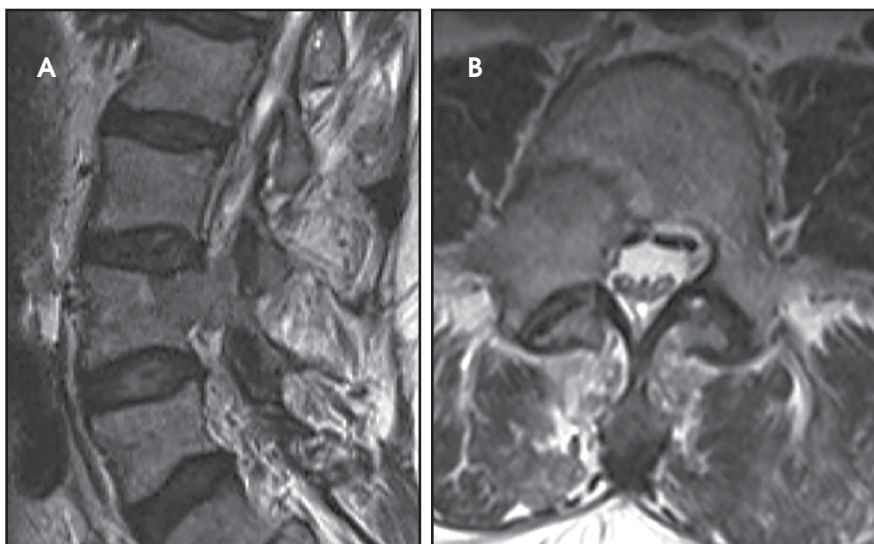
(A) Sagittal and (B) axial T2-weighted MR images of the lumbar spine upon presentation (12/2013) with lower extremity radicular symptoms. A lesion is present within the right posterolateral aspect of the L4 vertebral body, extending through the right pedicle and into the epidural space without effacement of the cauda equina.
